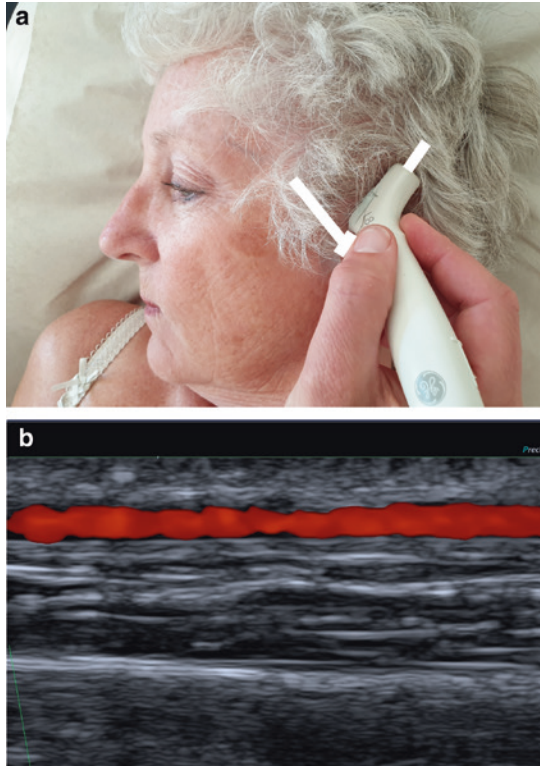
Examination of the parietal branch of the temporal artery: a recommended position of the transducer, b ultrasound image, longitudinal view
